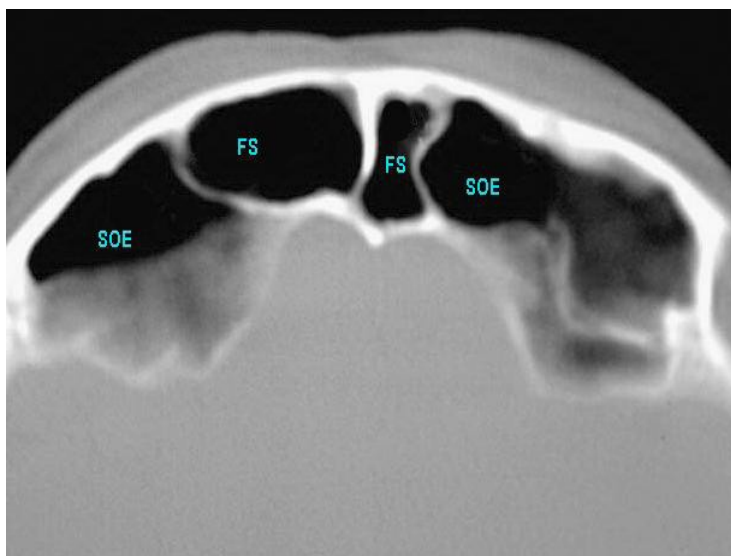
Axial CT showing supraorbital cell
